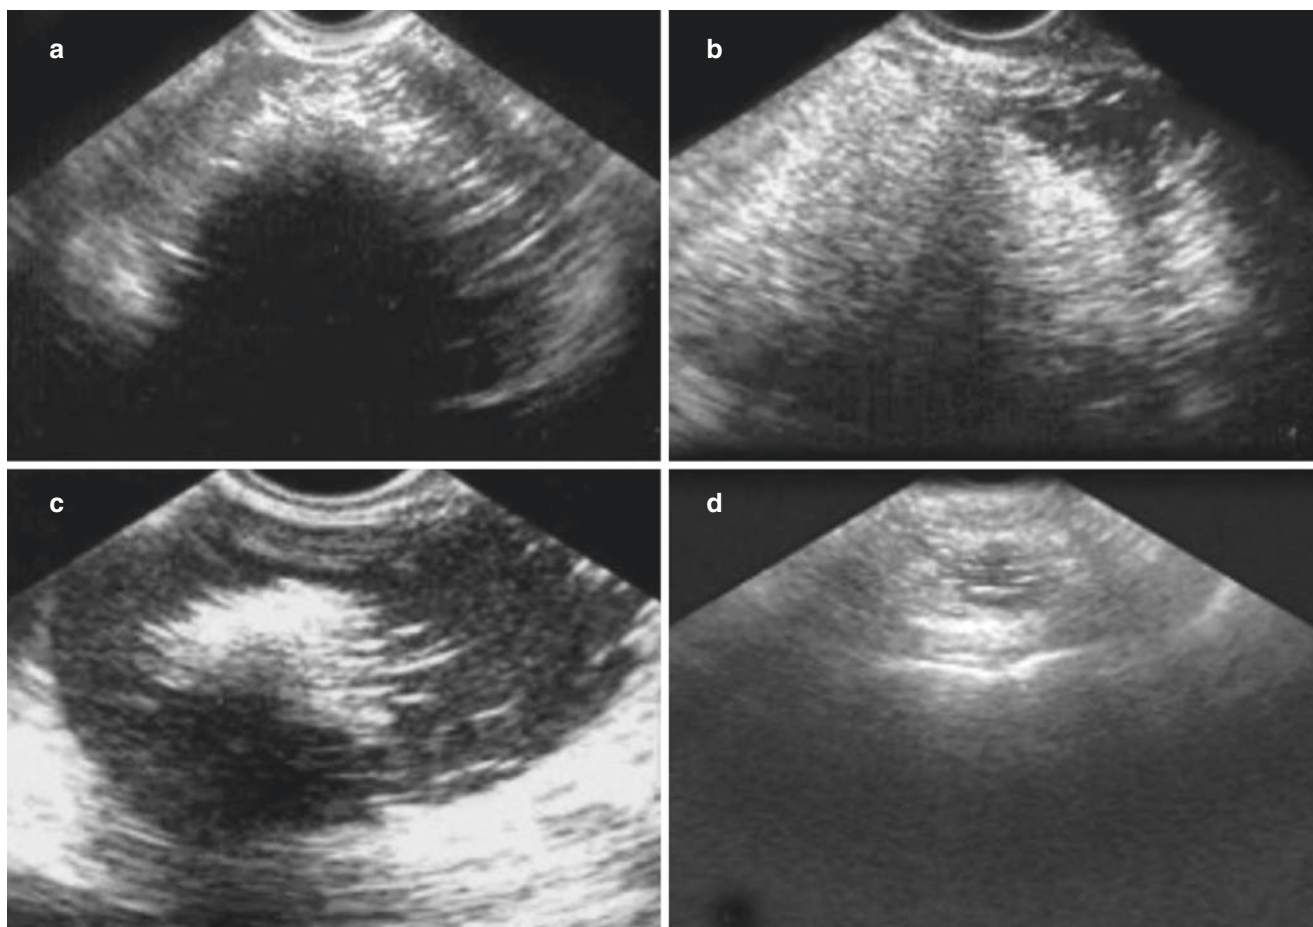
Ovarian teratoma (IV). (a-d) Ultrasonography shows an inhomogeneous mass with some hypoechoic areas. Hyperecho is often accompanied by attenuation shadow, resulting in unclear boundary
